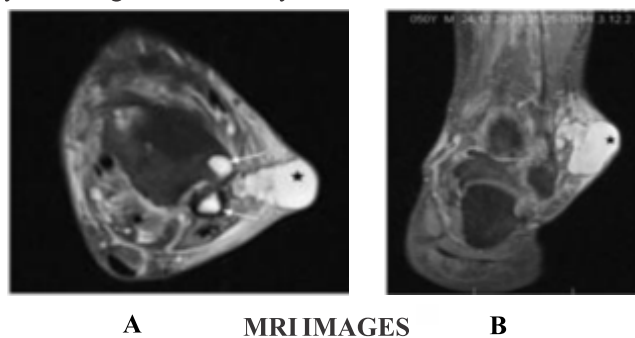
MRI scan of the above patient PD FAT SAT (A) Axial section & (B) Coronal section showing a hyperintense collection in the subcutaneous plane extending within adjacent fibula and tibia bone (arrow). There is extensive subcutaneous & intramuscular edema, all features are consistent with chronic osteomyelitic changes.
